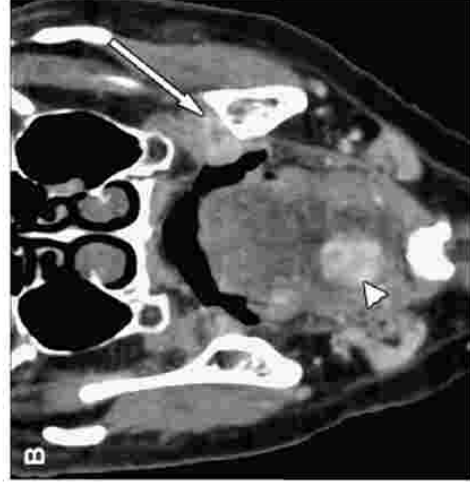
(A) The patient presented with a clinically evident SCC of the left retromolar trigone (arrow) for which a CT scan of the oral cavity was performed. (B) Incidental right base of tongue primary cancer (arrowhead) was discovered at imaging.
